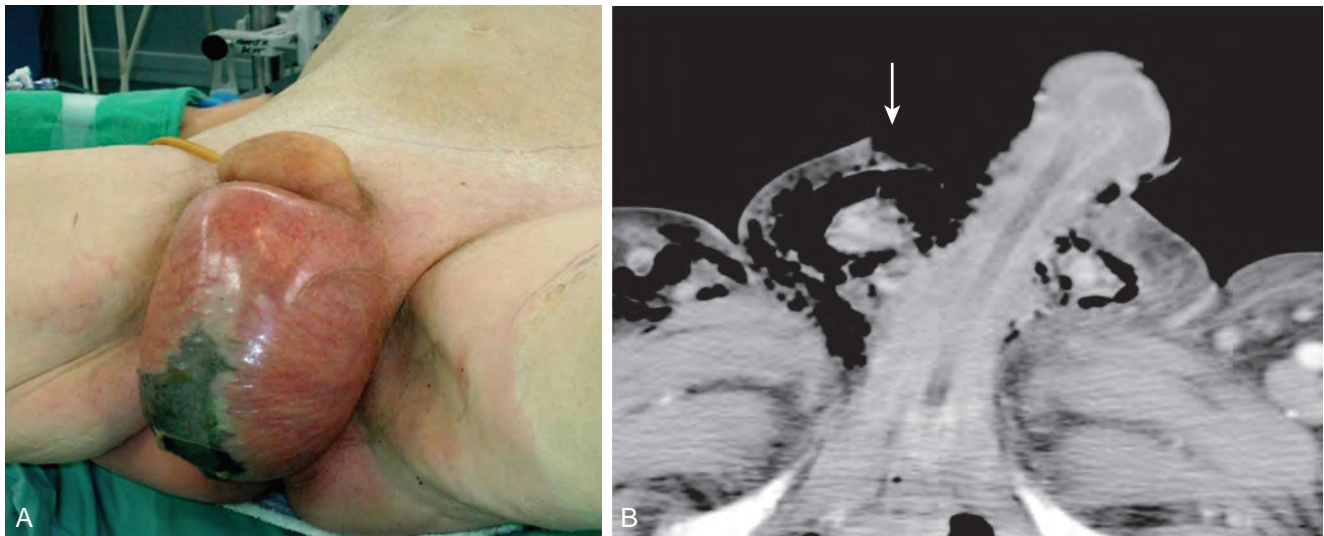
A, Large erythematous scrotum with central necrosis suggestive of necrotizing infection. B, Computed tomography scan reveals subcutaneous air in the scrotum (arrow) secondary to Fournier gangrene.
